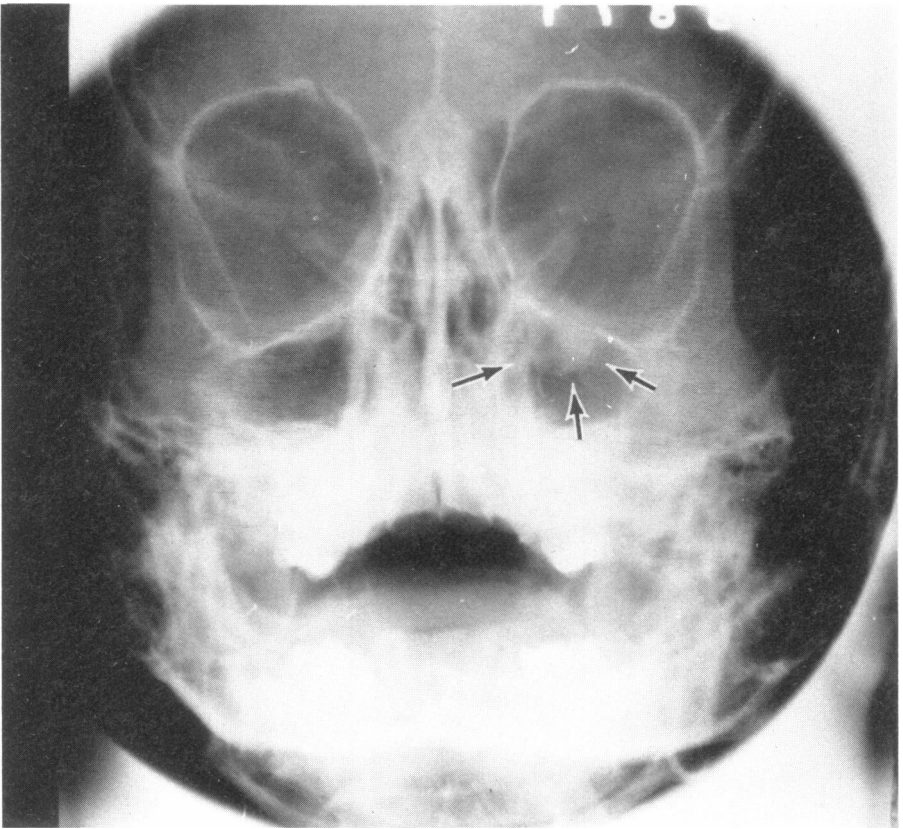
Maxillary sinus roentgenogram, Waters view. Blow-out fracture of left orbital floor (arrows).
